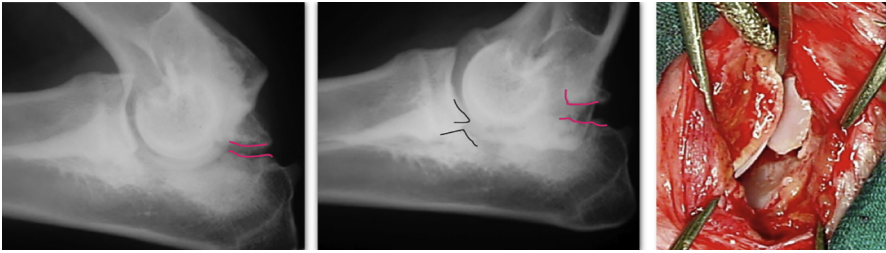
UAP stage IV. The process is not fused and is completely loose; the joint is usually incongruent with a shorter than normal ulna. Radiographically the radiolucency area seems to be wider and is accompanied by bone resorption of the anconeal process and ulna, which shows irregularities. The execution of 2 radiographs, in a midlateral neutral and midlateral hyperflexed position, allows evaluation of mobility of the anconeal process. In surgery, mobility of the anconeal process is appreciated.
